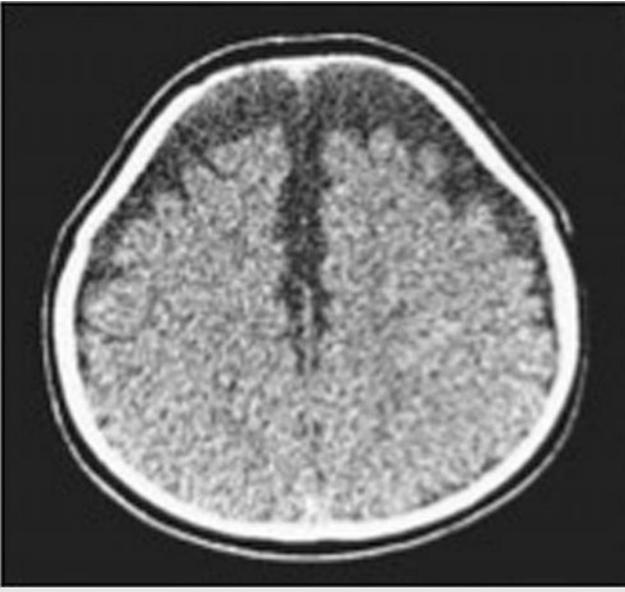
Axial noninfused computed tomographic scan of the head of a 3-month-old girl with right-sided heart failure and a bulging fontanel demonstrating enlargement of the subarachnoid space.
